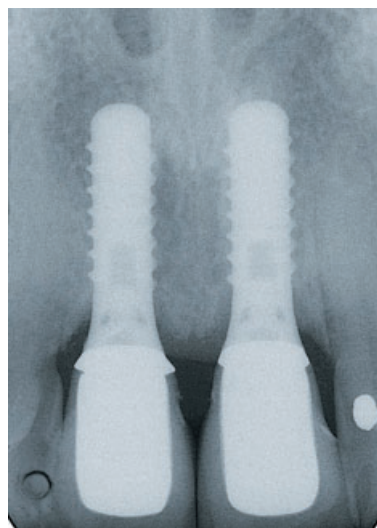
Six years after placement of the 12 mm solid screw titanium implants, the respective radiographs reveal stable conditions at the osseointegrated interface and adequate marginal adaptation.
